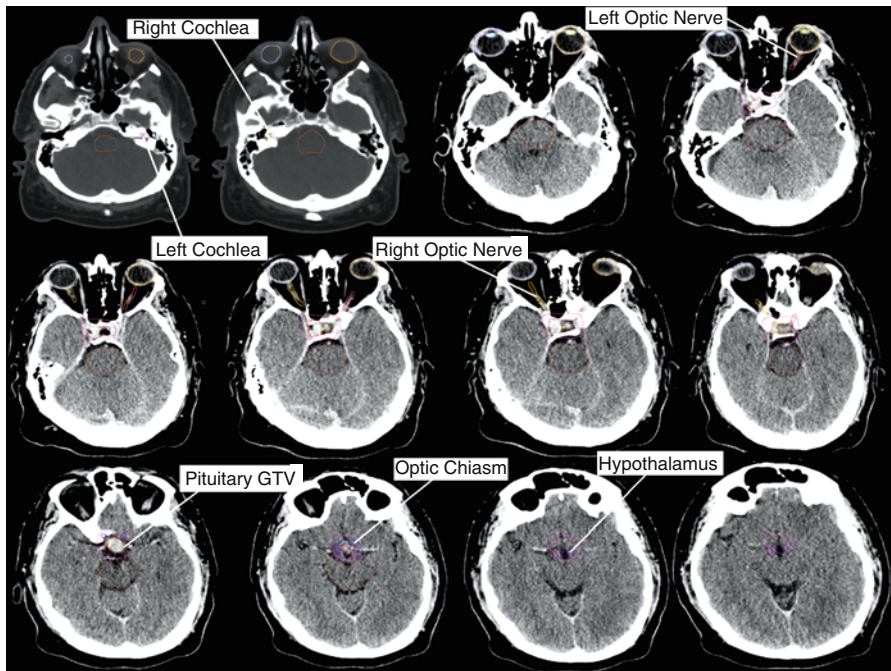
Pituitary adenoma with critical structure contoured on planning CT scan
